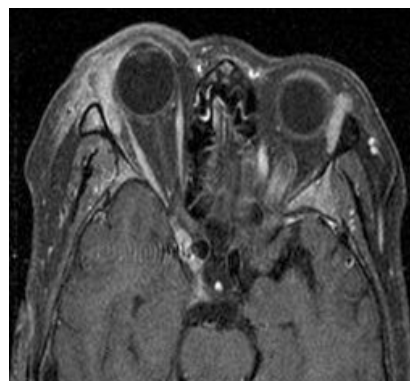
A granulocytic sarcoma from chronic myeloid leukemia in a 40-year-old man. A gadolinium-enhanced T1-weighted axial image shows bilaterally-enlarged masses with strong enhancement in the superior lateral aspect of both orbits. Soft tissue infiltrations are noted around the right orbit mass.
